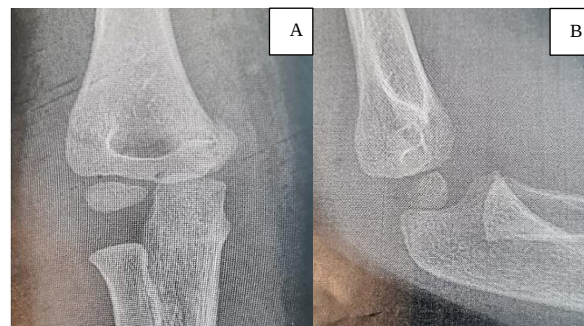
Anteroposterior (AP) (A) and lateral (B) views of the elbow radiographs before initial treatment
